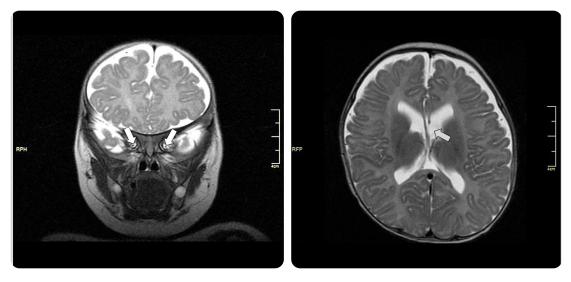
9 months old male patient with diagnosis of unspecified convulsive syndrome. a) T2 frFSE coronal MRI: bilateral hypoplasia of the optic nerve (arrows). b) Ventricular system, hypoplasia of left fornix.
